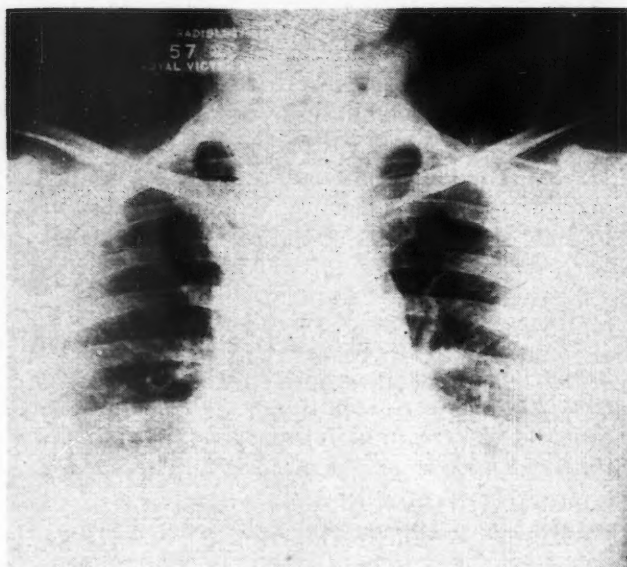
(Case 4).—Chest radiographs 24 hours following oesophagoscopy. Air was demonstrated in the subcutaneous tissues of the neck and in the mediastinum.
